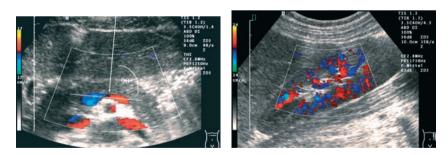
Color-Doppler image of the splenic vein. Flow towards the transducer in the distal part, red-coded; away from the transducer in the proximal part, blue. Note the gap of Doppler signals (90°!)
